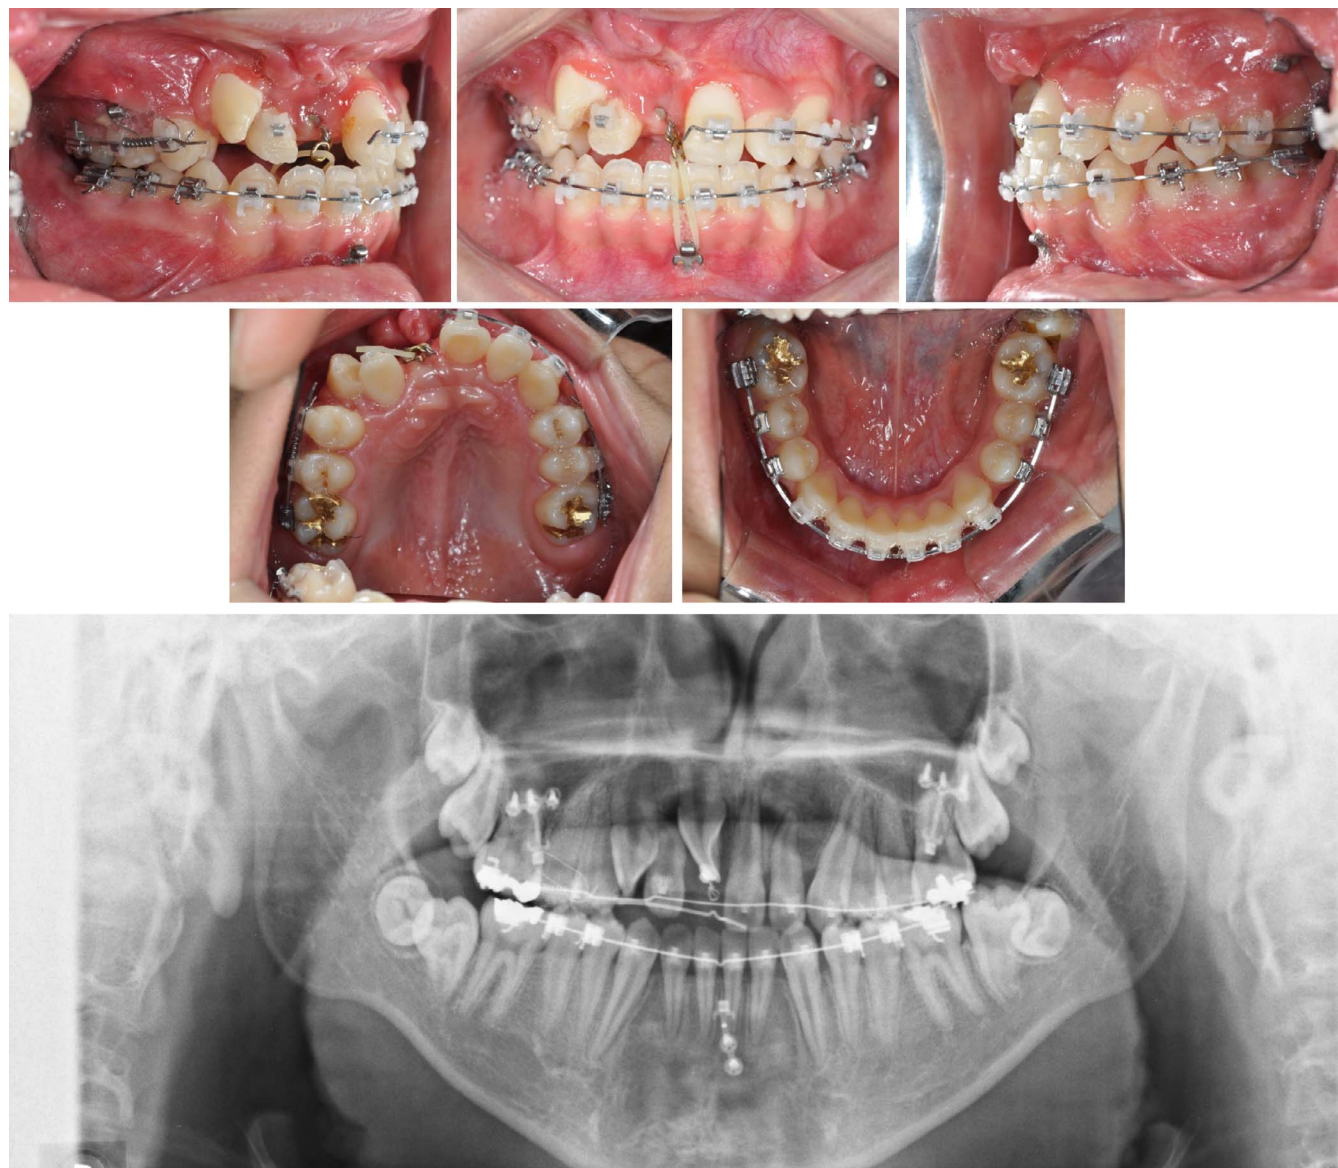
Intraoral photos and panoramic radiograph at 18 months after second surgical exposure and lingual button bonding of tooth 11.
